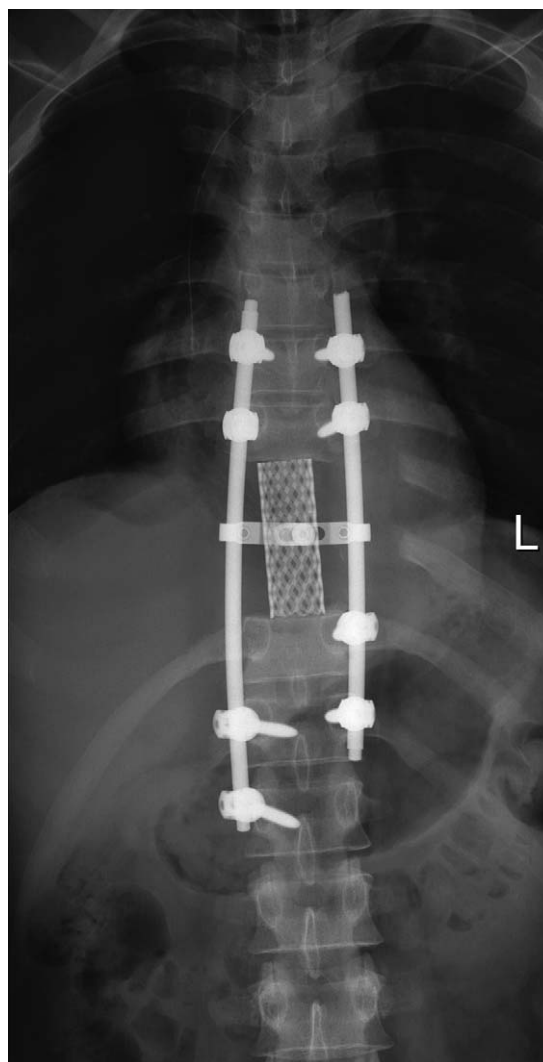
Radiograph showing wide resection of T9&10 with internal fixation.
